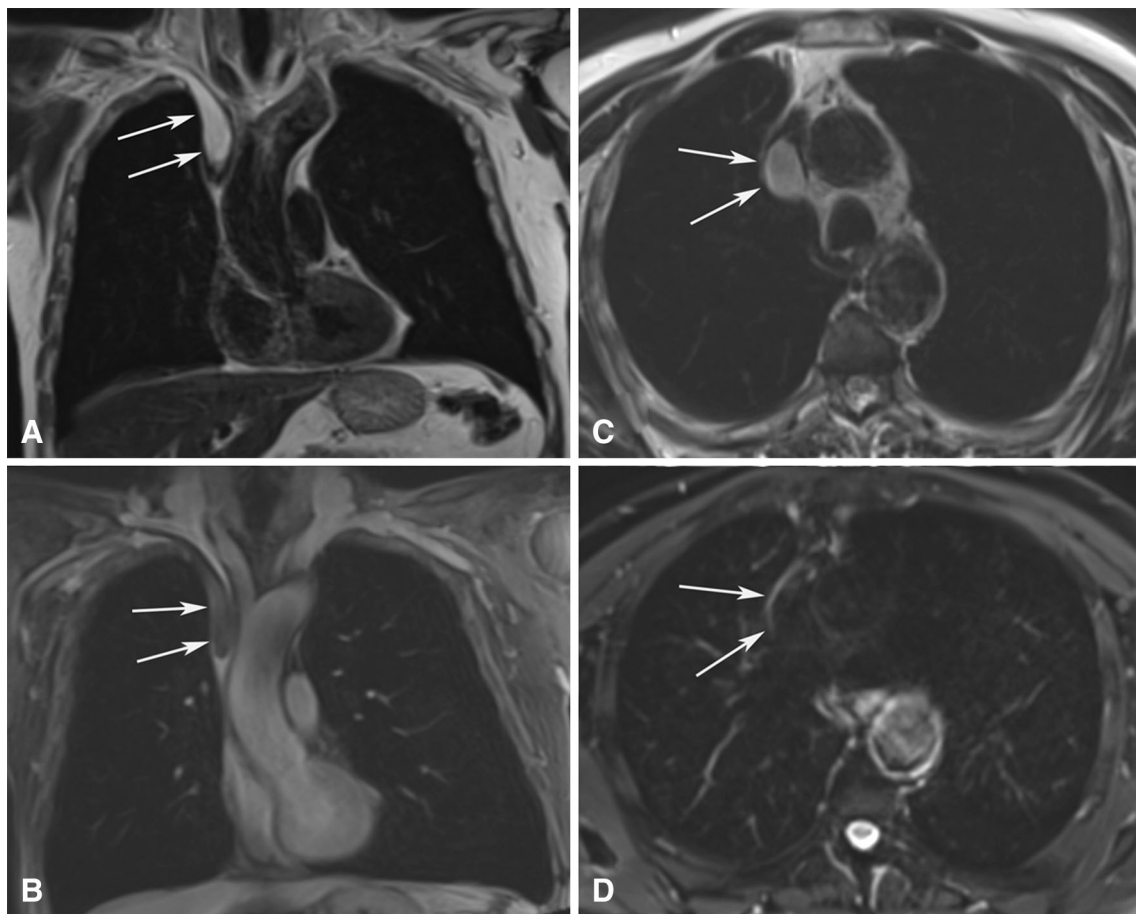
Coronal T2-weighted sequence without fat saturation (a) and post-contrast coronal T1-weighted sequence with fat saturation (b) demonstrate a homogeneous mass inside the right superior vena
